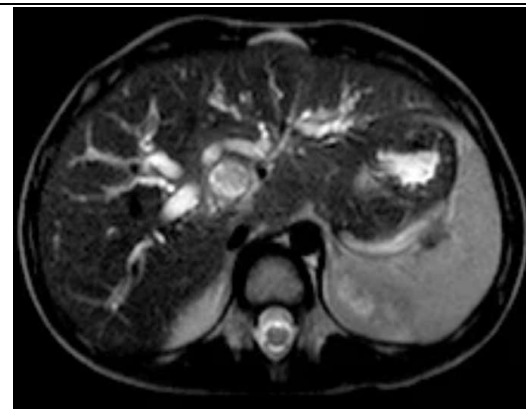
Axial MRCP image T2-weighted image showing intra- and extra-hepatic biliary dilatation.
